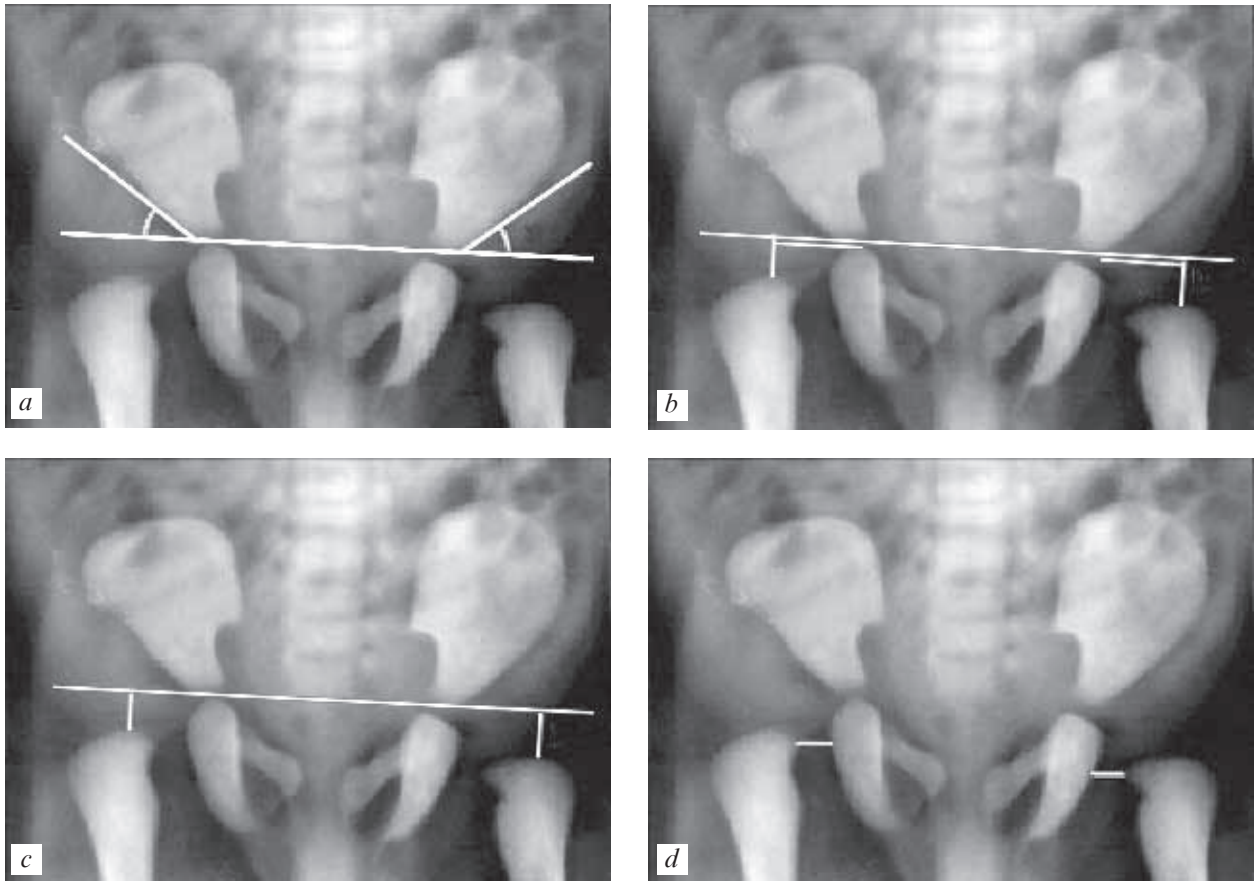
X-ray. Hilgenreiner-Erlacher scheme (a-d)
